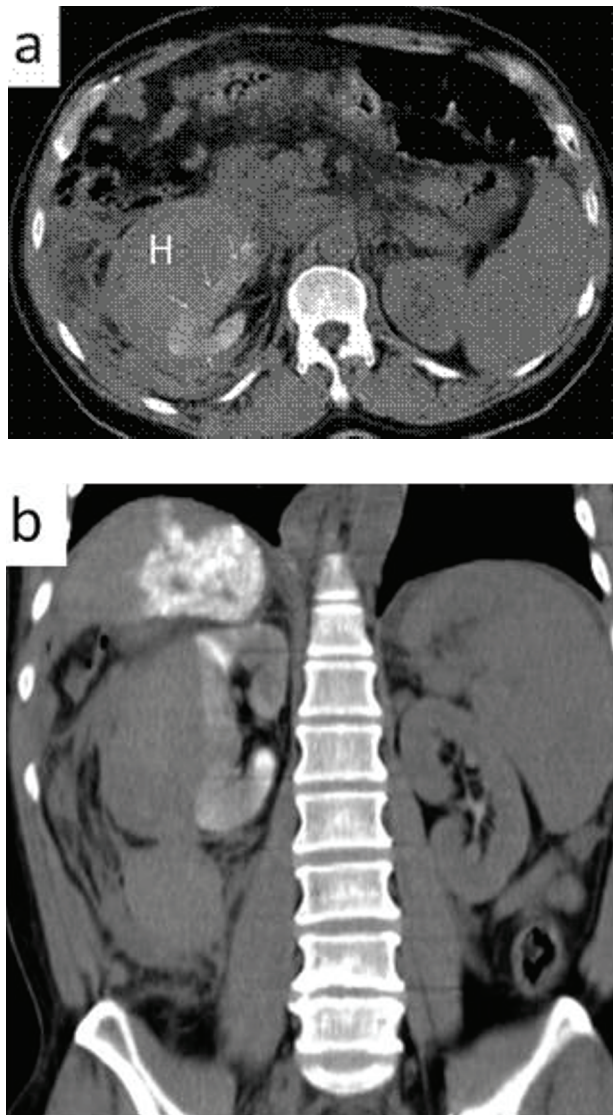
Abdominal CT scan without contrast enhancement. (A) Retention of contrast medium was found in the right kidney (arrow). There was evidence of subcapsular and peri-renal area hematoma (H). (B) A large area of lipiodol was collected in S7 segment of liver presenting lipiodol TACE for management of HCC
